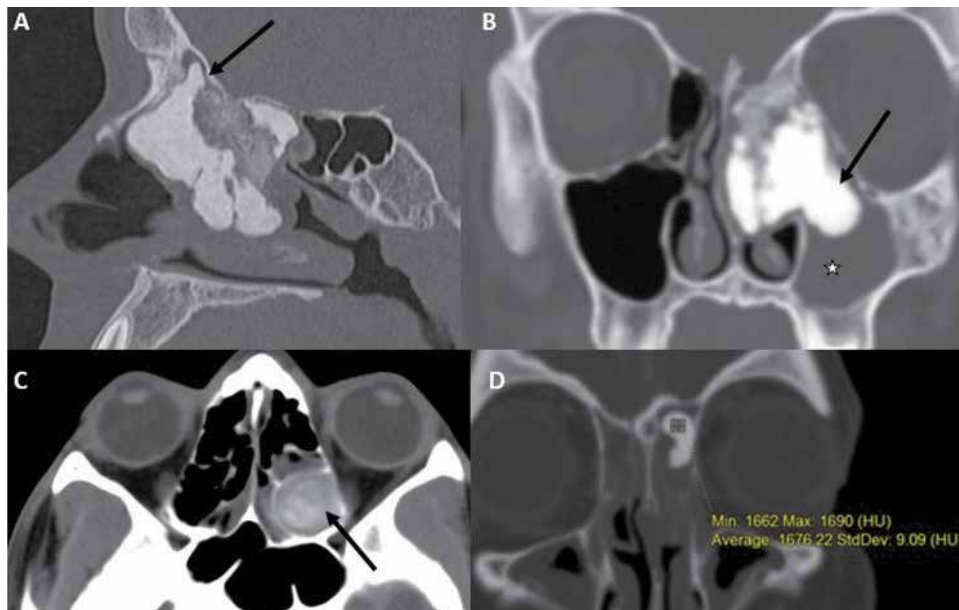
Osteoma: Sagittal image (bone algorithm, A) and coronal image (bone window, B) of the paranasal sinuses reveal a compact and trabecular sclerotic polypoidal osteoma (black arrows) in the left ethmoid and sphenoid sinuses, extending into the left maxillary sinus with associated occlusion of left osteomeatal unit and left maxillary sinusitis (asterisk). Osteoma can also present as a less dense mass, as depicted by the rounded heterogeneous dense mass in the left posterior ethmoid sinus on the axial CT image (C). Note the high Hounsfield unit of the osteoma (D).
